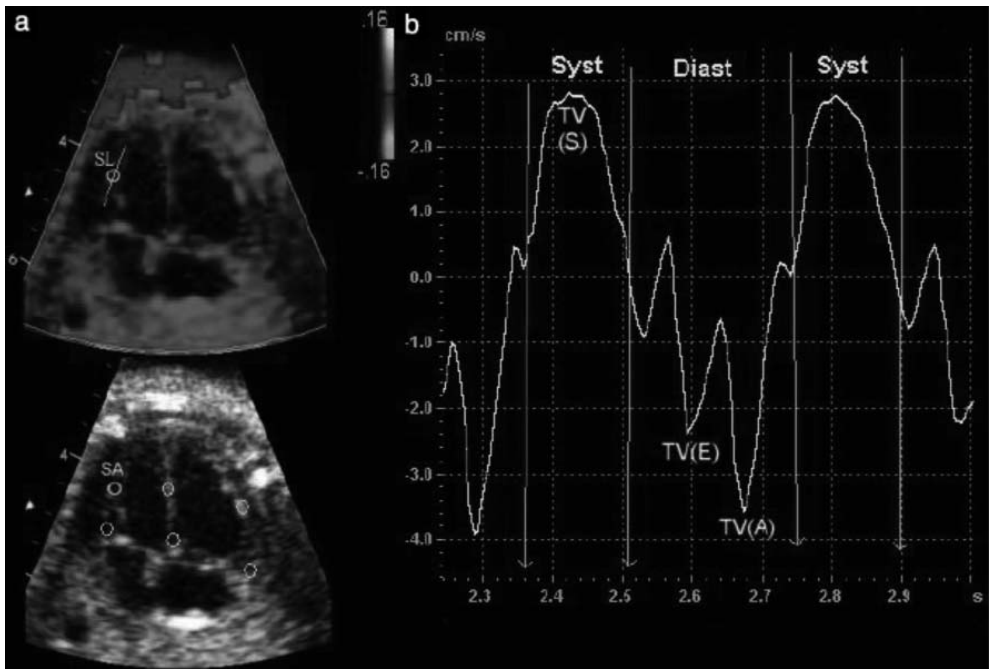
Four-chamber view in B-mode with color Doppler myocardial imaging superimposed. Red indicates movement toward the transducer and blue movement away from the transducer. (b) Example displaying tissue velocities of the middle portion of the left ventricular wall. SA, sample area; SL, strain length; TV(A), peak velocity during atrial contraction; TV(E), peak velocity during early diastole; TV(S), peak velocity during systole. Adapted from *Ultrasound Obstet Gynecol* 2006; 27: 210–213.
